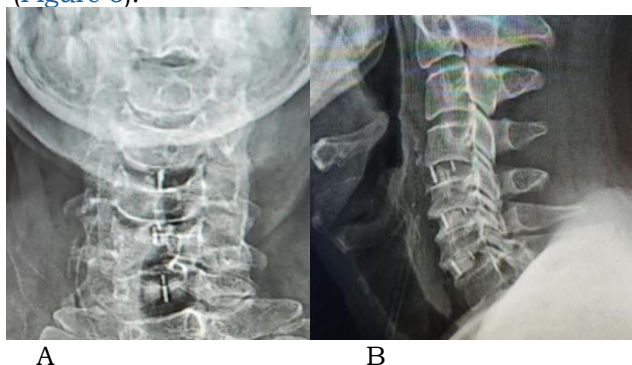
Immediate Post-Operative X-ray, A) AP view, B) Lateral view.
